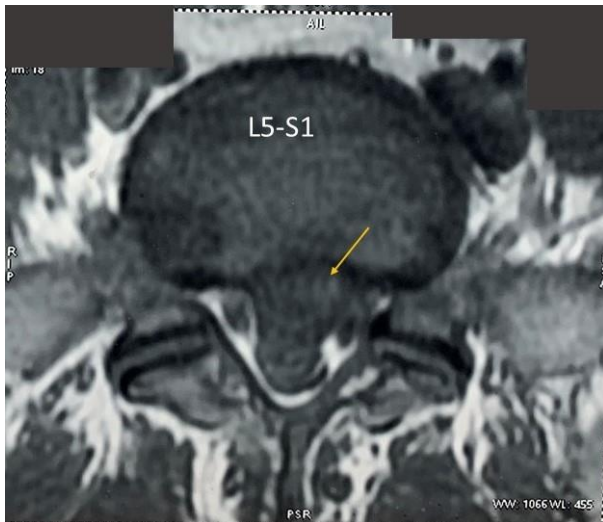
Pre-operative axial MRI image of the same patient as in figure-3, showing large postero-central disc herniation at L5-S1 level causing compression over ventral thecal sac (yellow-coloured arrow mark).
